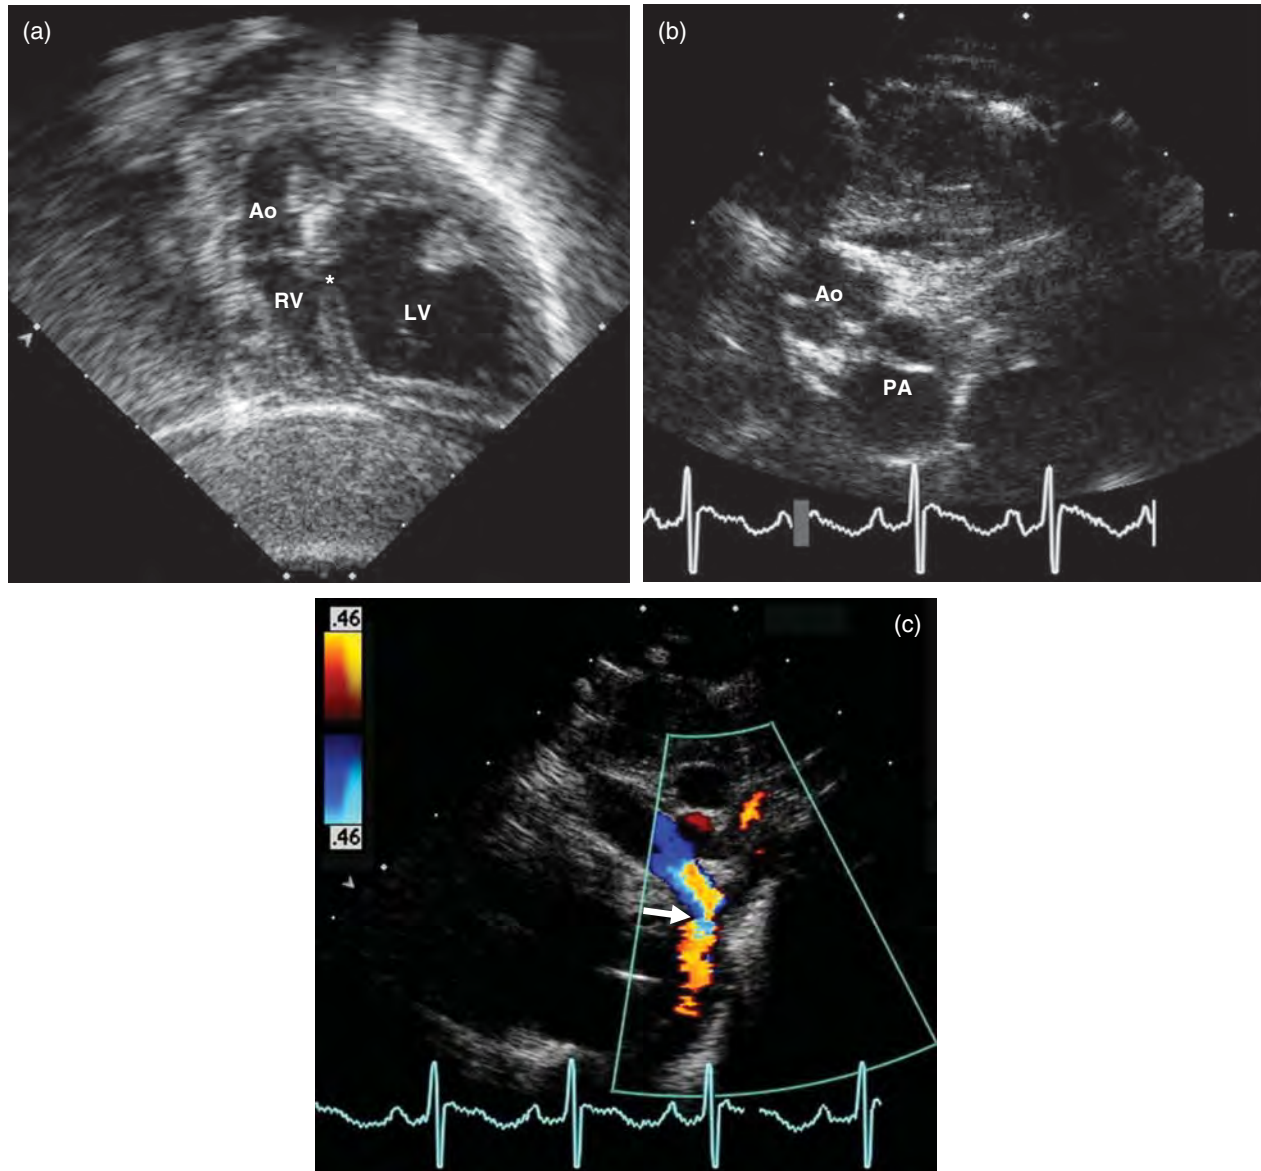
Type II-C tricuspid atresia. (a) The VSD is very restrictive (asterisk); the aorta arises from a hypoplastic RV. (b) The great arteries are transposed, with an anterior and rightward aorta. (c) Color flow Doppler of the aortic arch shows a discrete coarctation (arrow).
